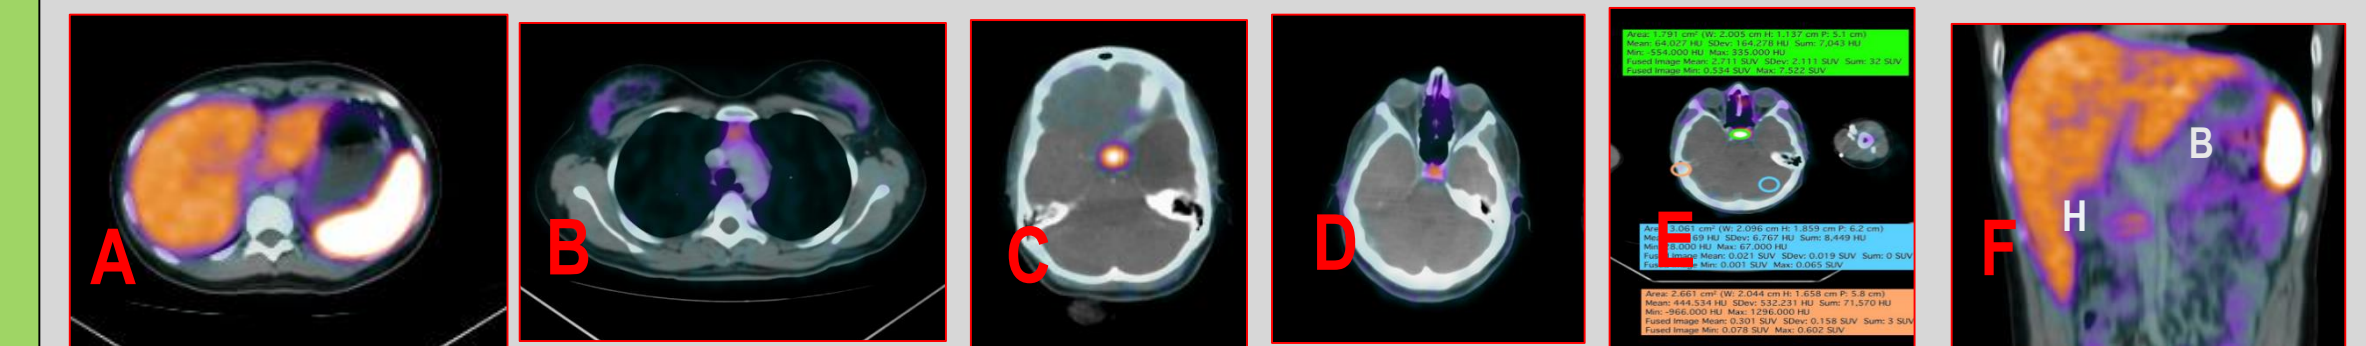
A- Highest uptake noted in spleen on trans axial PET/CT image. B-Mild to minimal uptake noted in mediastinum and thymic tissue. C-High uptake (SUVmax 12.1) in pituitary gland. D-low uptake in pituitary gland (SUVmax 1.3), showing variation in uptake pattern of pituitary gland. E-only area of high uptake in brain is pituitary gland while uptake in cerebellum and cranial vault is minimal. F-coronal PET/CT fused image showing more Ga 68 DOTANOC uptake in pancreatic head H (SUVmax 3.0) as compared to pancreatic body B (SUVmax 1.2).
